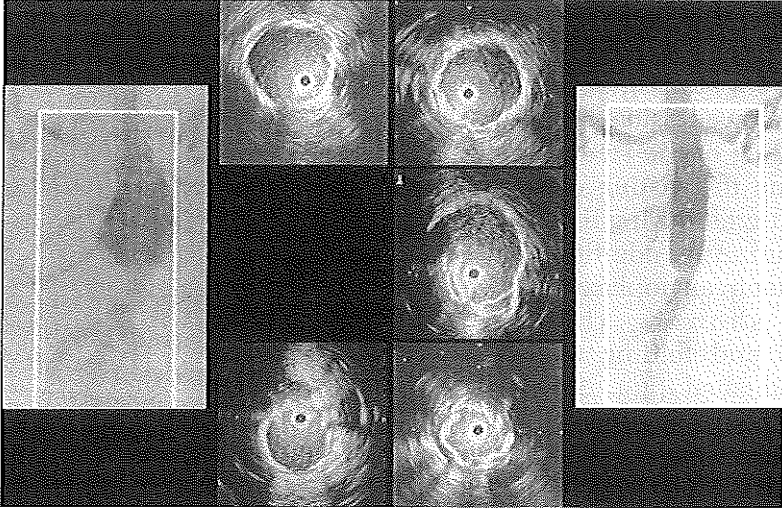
Intravascular ultrasound (IVUS) cross-sections from the proximal and distal neck before (left panel) and after placement (right panel) of an Ancure endovascular tube graft. Before intervention the diameter of the proximal neck was 18 mm and of the distal neck was 15 mm. Corresponding IVUS images obtained after implantation, showed good apposition at the proximal neck and folding of the stent-graft at the level of the distal neck. The inserts show the preoperative (left) and postoperative angiogram (right) showing the outline of the endovascular graft and tapering at the distal end. Calibration = 5 mm.
